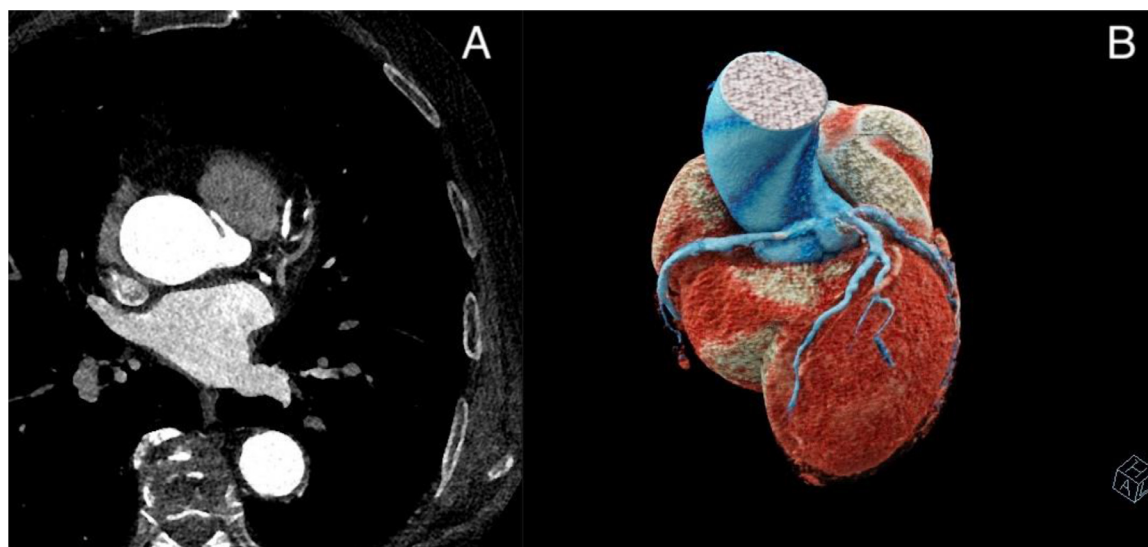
Computed Tomography (CT). (A) Axial CT image showing right coronary artery (RCA) originating from left coronary sinus. RCA has a inter-arterial course between aorta (A) and pulmonary artery (PA). (B) Volume-rendered (VR) image of the heart demonstrates both the right and left coronary arteries originating from left coronary sinus
